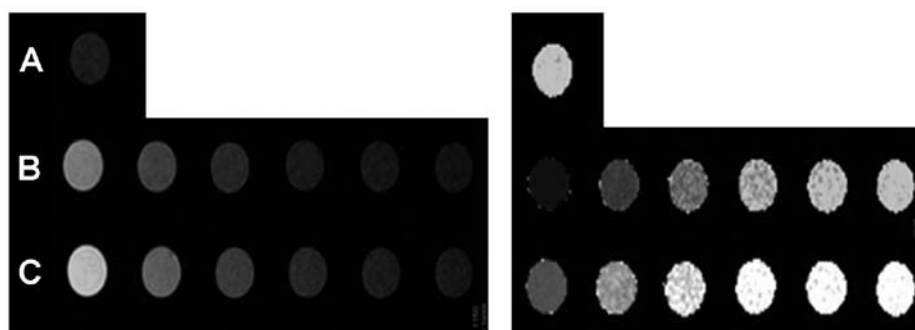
T1-weighted images (left) and T1-map images (right) of different gadolinium (Gd) concentration of anti-epidermal growth factor receptor-internalizing arginine-glycine-aspartic acid-diethylene triamine pentaacetate-Gd (anti-EGFR-iRGD-DTPA-Gd) and Gd-DTPA. The concentration of Gd was 77, 38.4, 19.2, 9.6, 4.8 and 2.4 μM , respectively. (A) Saline, (B) anti-EGFR-iRGD-DTPA-Gd and (C) DTPA-Gd.
